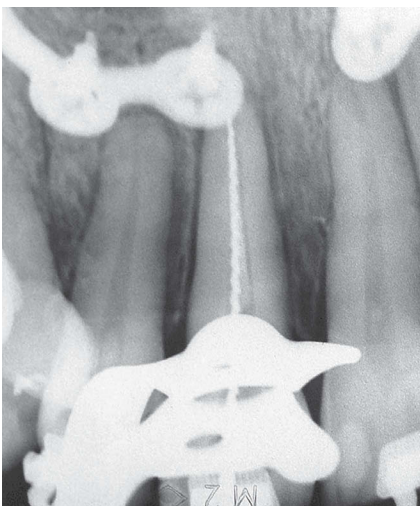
Periapical radiograph and CBCT for odontometry determination.
